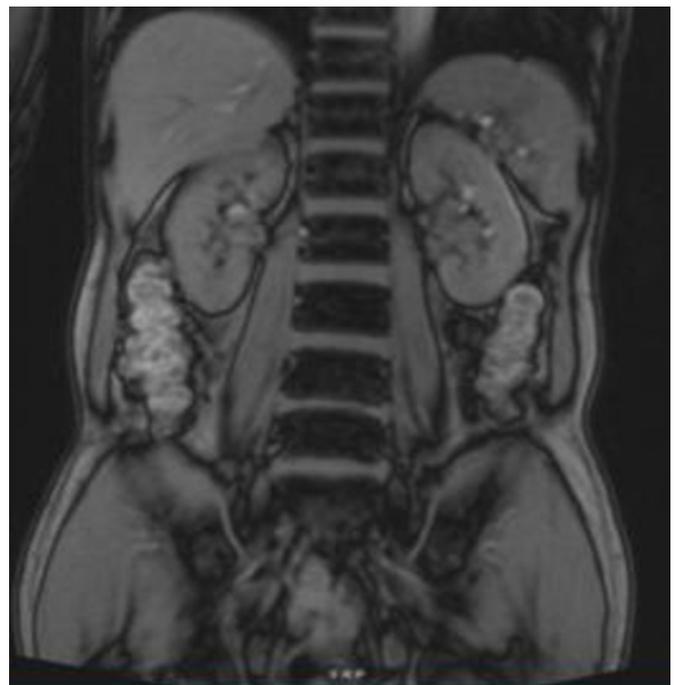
MRI taken approximately 1-year postdupilumab treatment showed dramatic resolution of fibrosis.
